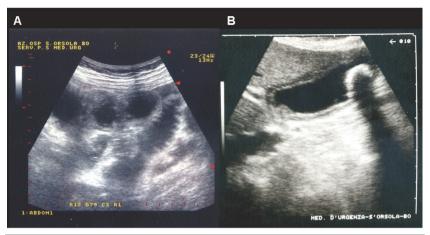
External abdominal ultrasonography. A) Dilation of small bowel loops associated with bowel wall thickness, presence of fluid-fluid levels and thickness of valvulae conniventes; B) presence of large gallstone.
